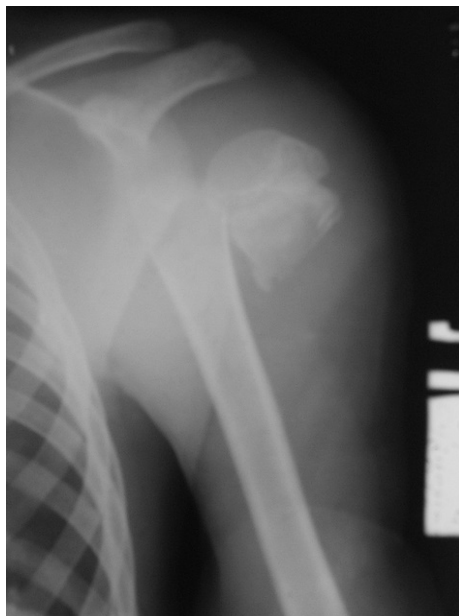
The radiograph of the humeral joint in a direct projection. In the area of the surgical neck of the humerus fracture with cross-section displacement to lateral direction (on the width of metaphysis). Proximal fragment is displaced downwards. Total discrepancy of surfaces in the humeral joint. Fracture of the humeral bone surgical neck. Back dislocation of the shoulder
